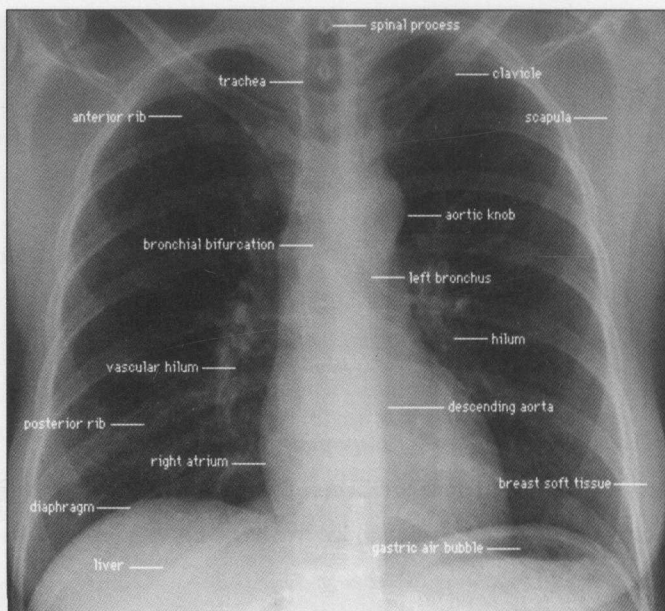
Normal radiographic anatomy of the chest presented on the posteroanterior film
